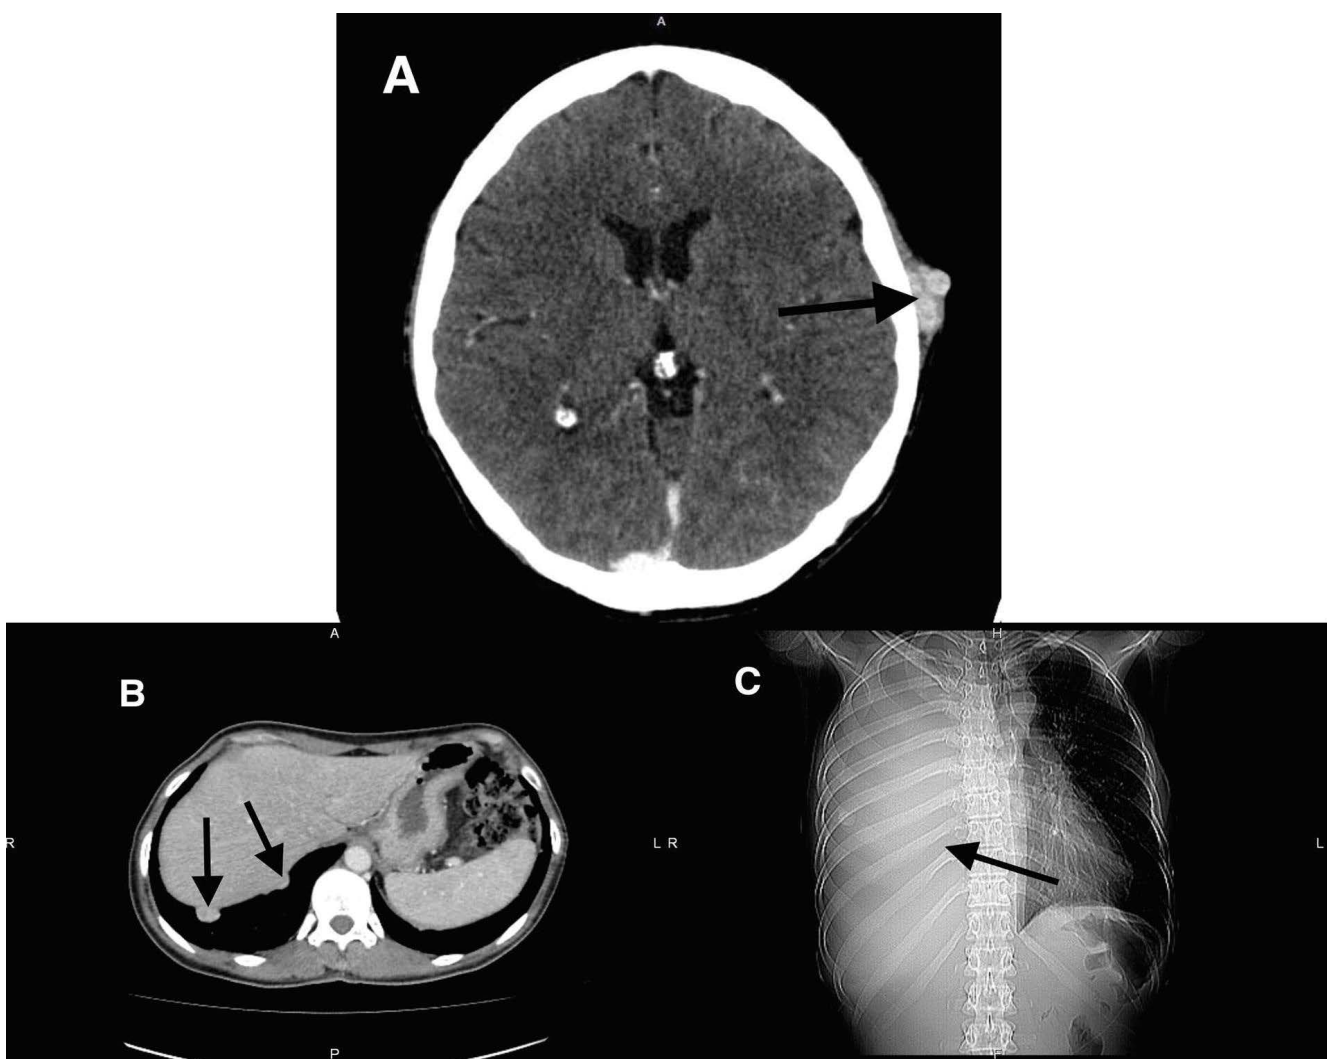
Diagnostic imaging showing metastatic masses: (A) Axial head CT scan showing a subcutaneous metastasis in the left temporal area (arrow). Pathology report concluded the mass consisted of undifferentiated cancer cells; (B) Axial contrast-enhanced abdominal CT scan showing subpleuritic masses, demonstrating strong contrast enhancement (arrows); (C) AP chest X-ray - massive right-sided pleural effusion, atelectasis, and displacement of the mediastinal structures to the left (arrow).
